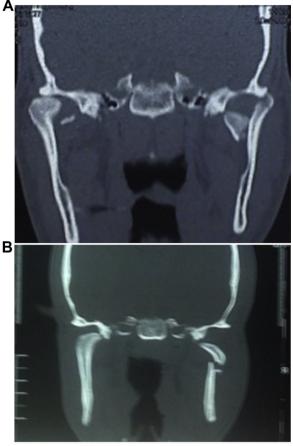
Coronal CT scans representing condylar fractures.
